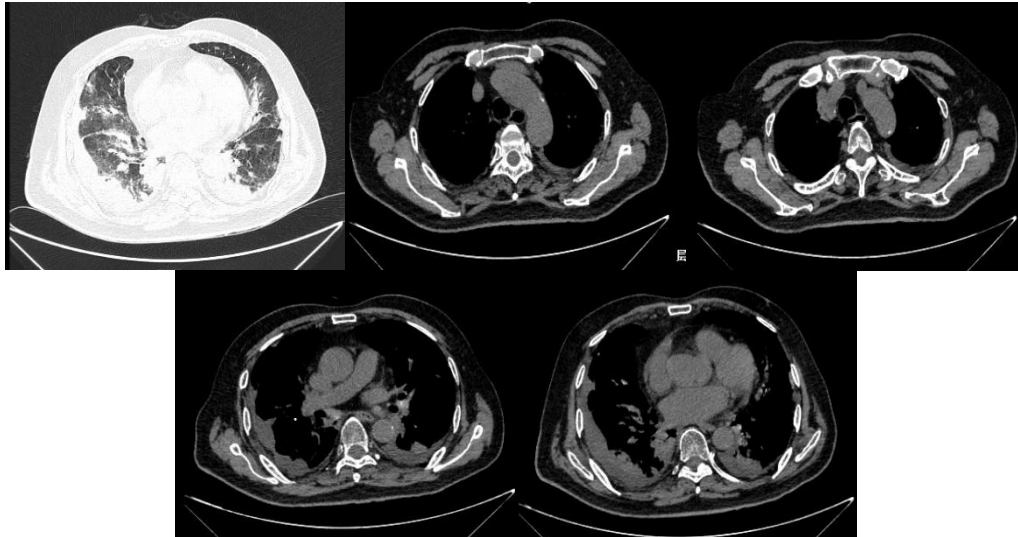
Patient 2023.11.24 Chest CT
